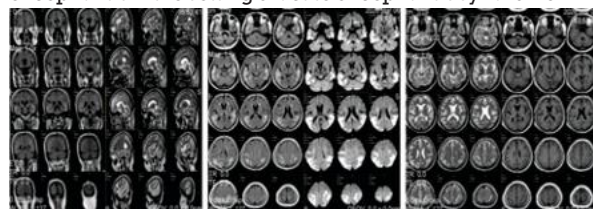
Magnetic Resonance Imaging (MRI) of the Brain Revealed Asymmetric Involvement of the Bilateral Medial Temporal Lobes, with Predominant Involvement on One Side. The Affected Regions Included the Hippocampus, Amygdala, and Parahippocampal Gyrus, with Extension into the Insula and Inferior Frontal Cortex. On T2-weighted and FLAIR Sequences, there were Hyperintense Signal Changes in the Involved Cortical and Subcortical Regions. Corresponding Areas Appeared Hypointense on T1-weighted Images. Diffusion-weighted Imaging (DWI) Demonstrated Areas of Restricted Diffusion, Consistent with Cytotoxic Edema.
